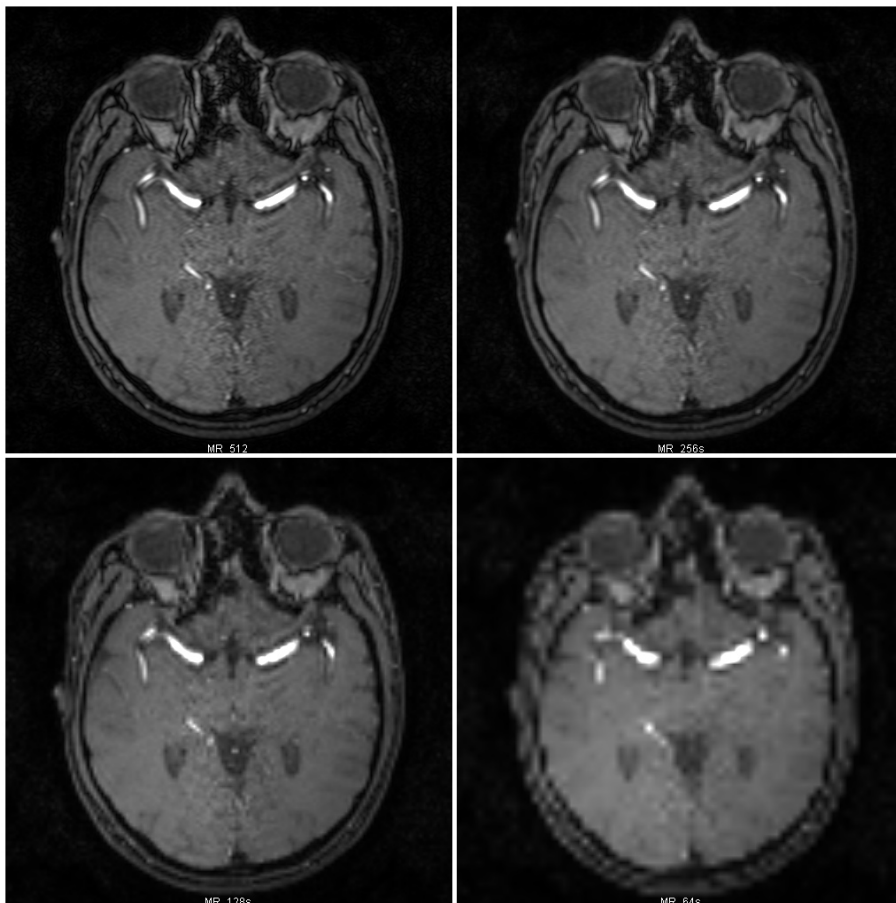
Sample set of corresponding image slices from a set of successively downsampled MRI angiograms. The original (512x512 px.) at top left. Approx. 1:2 scale
